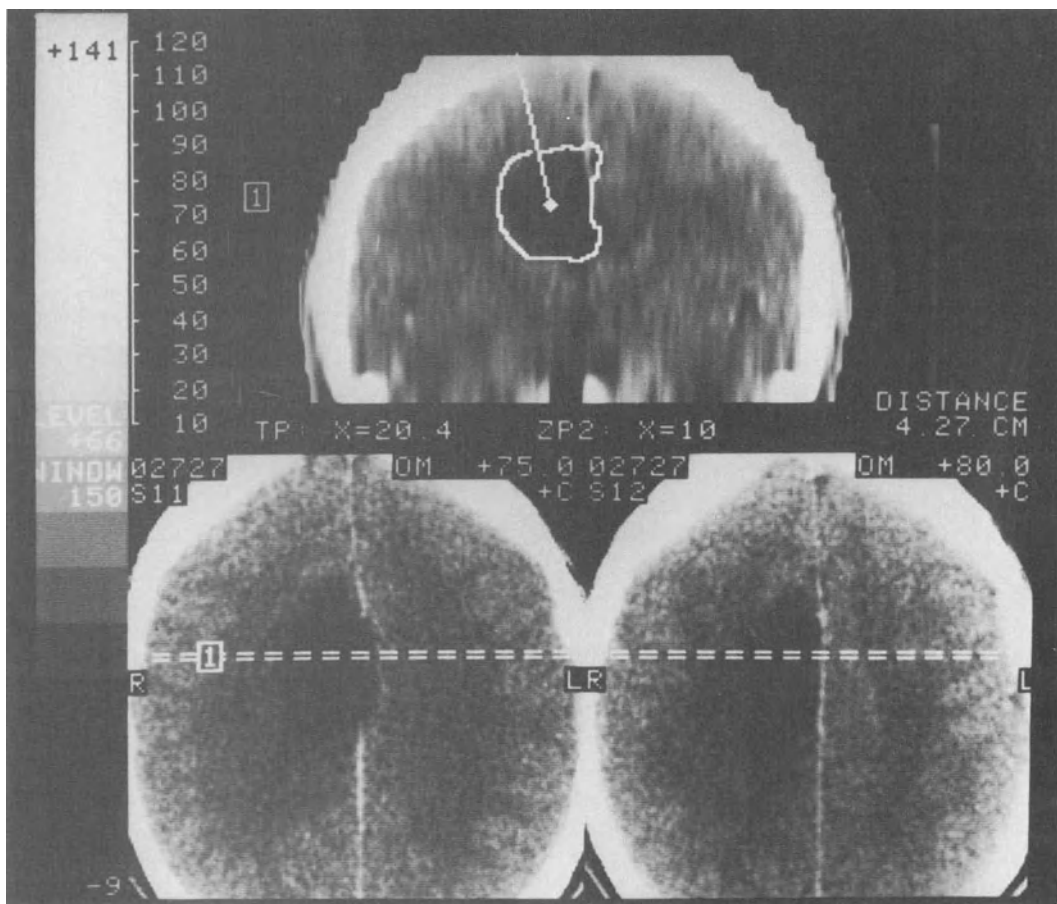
CT coronal reconstruction of brain tumor in figure 2-9, used to obtain the X coordinates of the implantation and trephination points.
